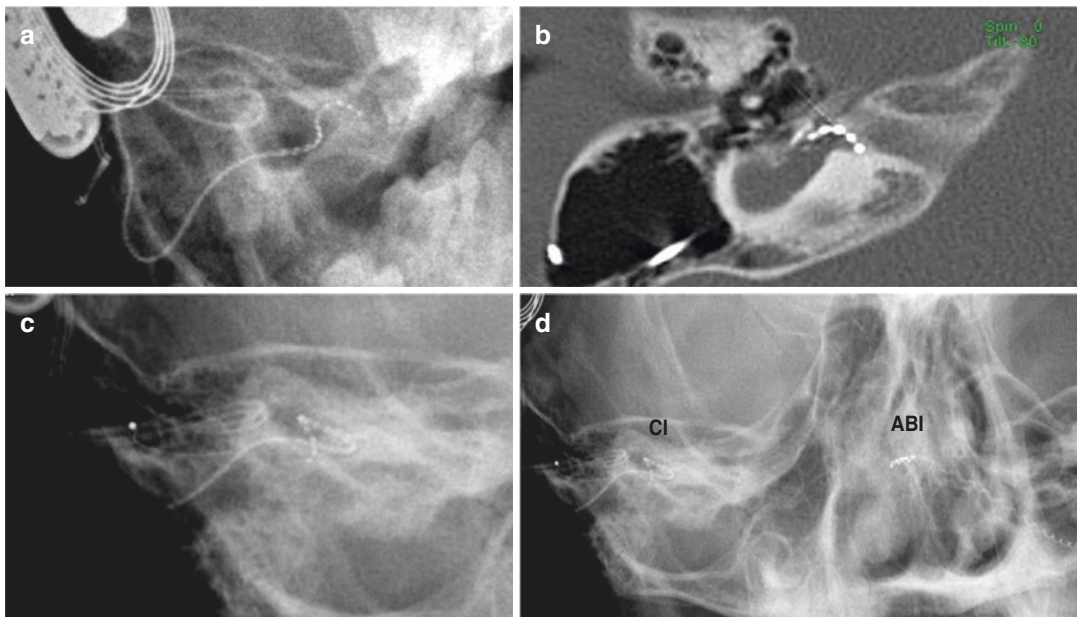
(a) Transorbital X-ray demonstrating electrode placement towards IAC, (b) HRCT showing the tip of the electrode to be in the vicinity of the labyrinthine
